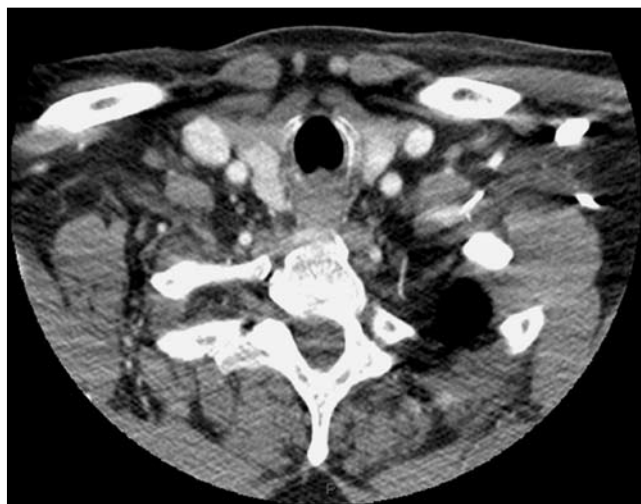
Baseline CT of the neck at the time of onset of symptoms.
